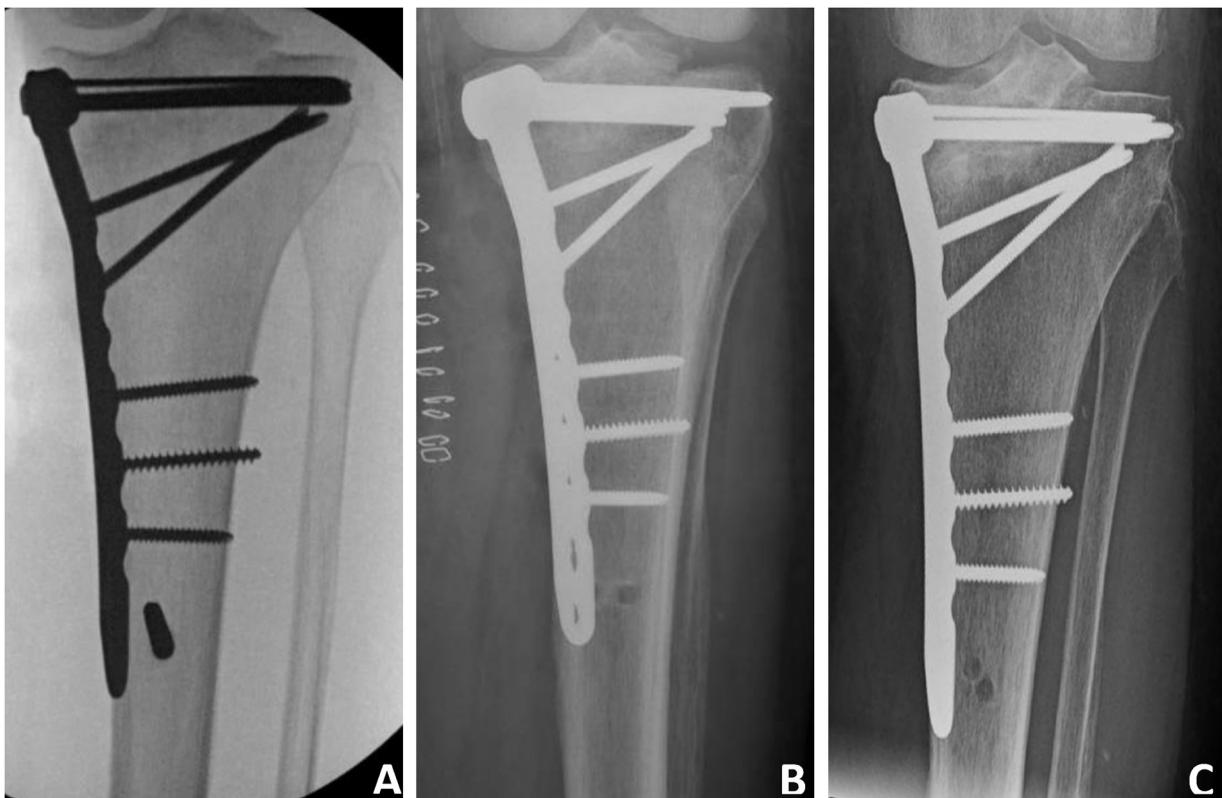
Representative intraoperative fluoroscopic image (A), post-operative PACU radiograph (B), and one-year follow-up radiograph (C) from a single patient.
